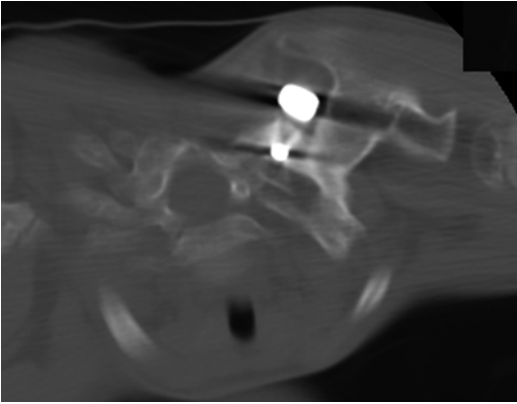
Unintended scapula to thoracic fusion. Scapulothoracic stiffness is common, and occasional fusion between the ribs and scapula in the area of the upper thoracic rib attachment can occur. In this example, expansion thoracostomy and VEPTR insertion were done for severe congenital scoliosis and extensive unilateral rib fusions. Increasing shoulder stiffness was noted at age 6. CT showed bony fusion between the scapula and ribs and upper portion of the device. Revision with resection of the bony bridge and physical therapy improved scapulothoracic motion somewhat
